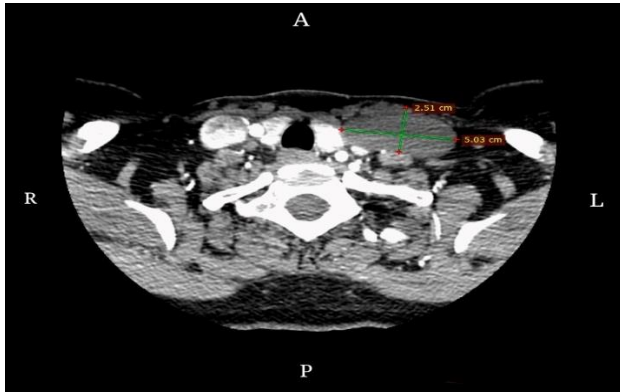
Axial section of CTA head and neck showing cystic lesion over the left supraclavicular region.
